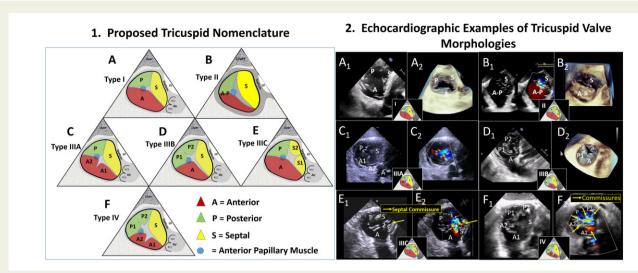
Tricuspid valve nomenclature classification scheme. A proposed Tricuspid Valve Nomenclature Classification scheme is shown in the left panel (1). The anterior papillary muscle is indicated as a blue circle and defines the separation of the anterior from the posterior leaflets. (A) The Type I, 3-leaflet configuration. (B) The Type II, 2-leaflet configuration. (C and D) The Type III, 4-leaflet configurations. (F) The Type IV, 5-leaflet configuration. The panel on the right (2), shows echocardiographic examples of the tricuspid valve morphologies and the letter labels correspond to the proposed nomenclature in the left panel. (A1 and A2) Type I morphology by 2D and 3D imaging. (B1 and B2) Type II morphology by 2D and 3D imaging. (C1 and C2) Type IIIA morphology by 2D imaging without and with color Doppler. (D1 and D2) Type IIIB morphology by 2D and 3D imaging. (E1 and E2) Type IIIC morphology by 2D imaging without and with color Doppler. (F1 and F2) Type IV morphology by 2D imaging without and with color Doppler. (F1 and F2) Type IV morphology by 2D imaging without and with color Doppler. (A superior leaflet, S = septal leaflet, LV = left ventricle, AV = aortic valve, NCC = non-coronary cusp, RCC = right coronary cusp. Reproduced with permission from Hahn et al^{21}
